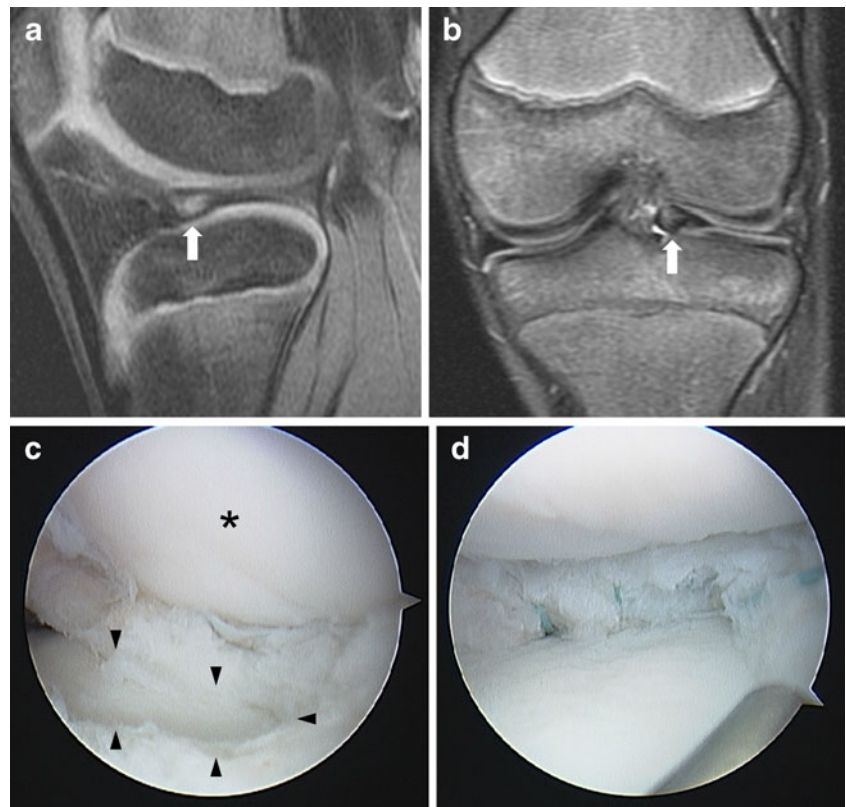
A 12-year-old boy. Sagittal and coronal T2 images in this arthroscopically proven Wrisberg variant discoid lateral meniscus demonstrating absent struts of the popliteomeniscal fascicles (*arrows*), which has been reported as a key MRI finding in the nontorn, nonsubluxated Wrisberg variant meniscus
